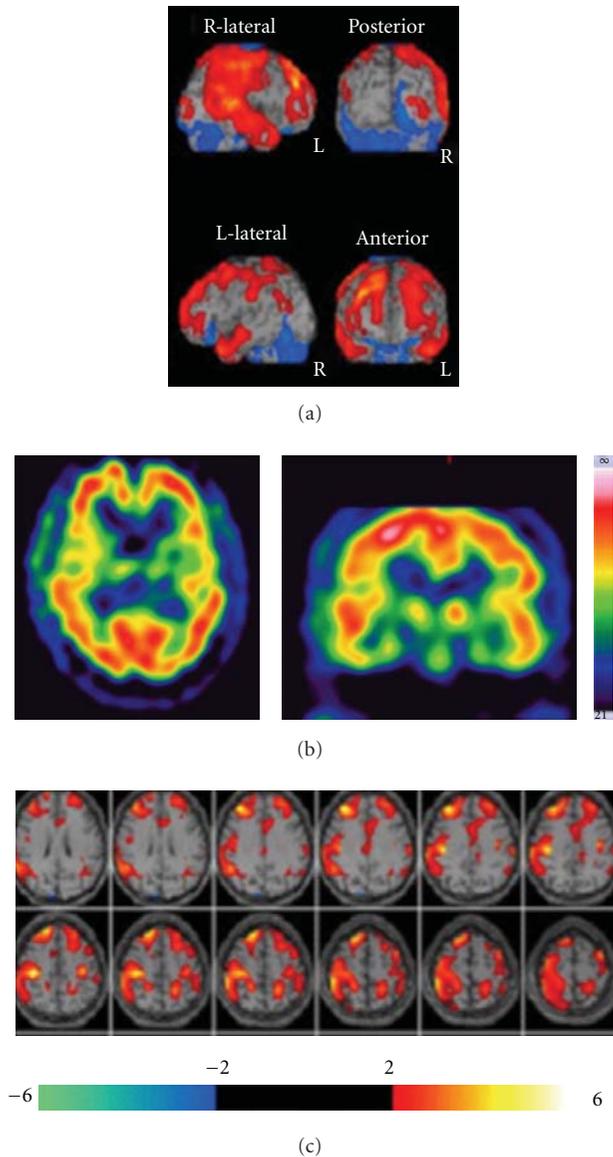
Brain ^{99m}Tc -ECD SPECT imaging after lomerizine treatment. As compared to pretreatment with lomerizine, CBF is increased in the bilateral frontoparietal regions on eZIS imaging. Cerebral hypoperfusion is improved markedly.
